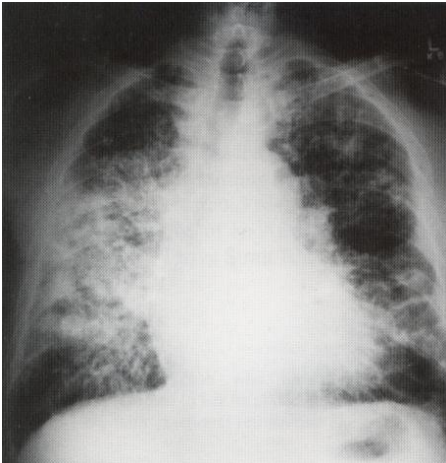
Chest radiograph of patient 2 showing parenchymal lung changes and predominantly right hilar adenopathy consistent with Stage II sarcoidosis.
